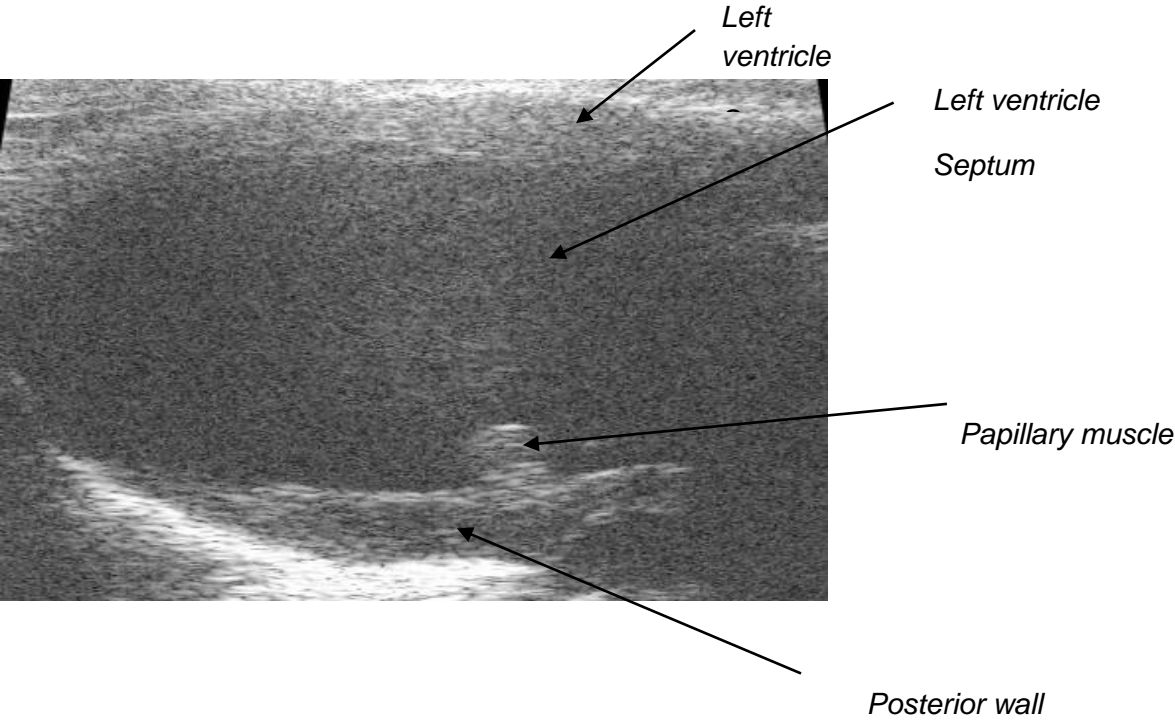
2D Pictures. Parasternal long axis view: left ventricle.
